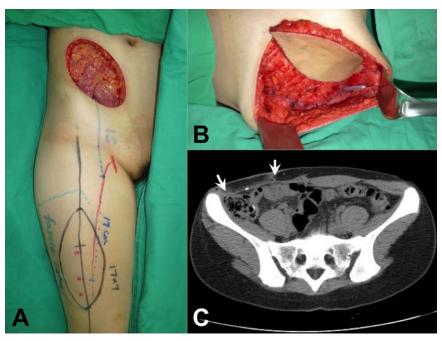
Case 1. A: Full-thickness defect and ALT-FC flap design. B: A large fascia lata component was included and inset using permanent sutures. C: Postoperative CT revealed excellent integration of the fascia component into the native abdominal wall (arrows). No bulge or hernia was noted 6 months after surgery.
